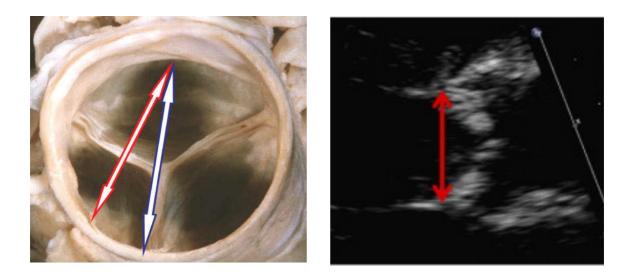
Anatomic and bidimensional echocardiographic view of human aortic root. Echocardiographic measurement does not transect the full diameter of the annulus (blue arrow) but takes into consideration a shorter cut (red arrow) (1).
